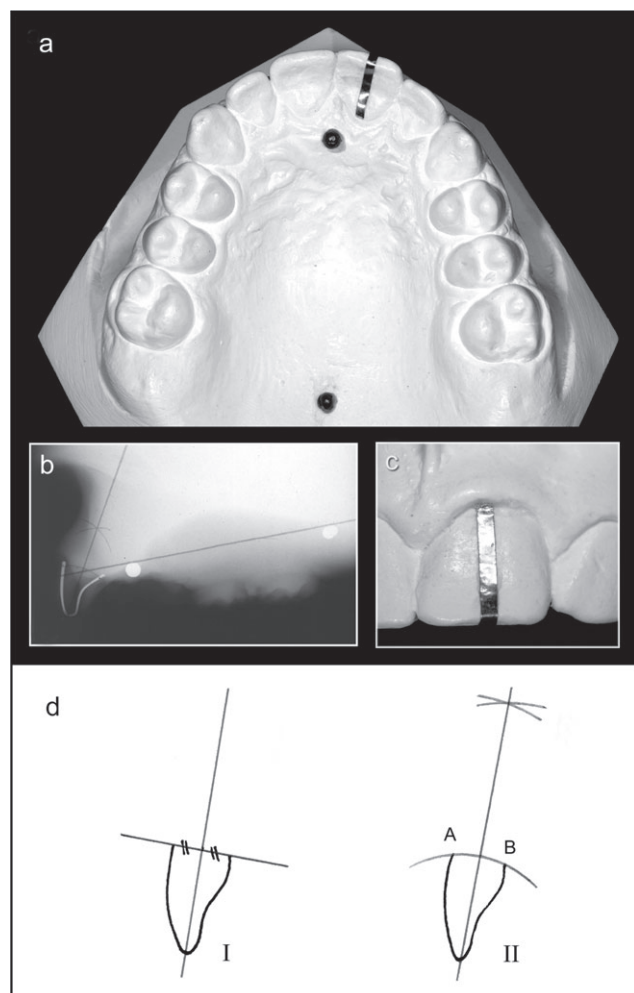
(a) Dental cast with lead film-strip and reference points on the palate. (b) Standardized radiograph of a dental cast. (c) Lead film-strip on the left upper central incisor. (d) Two measuring methods to determine the incisal inclination line (see Table 1).
